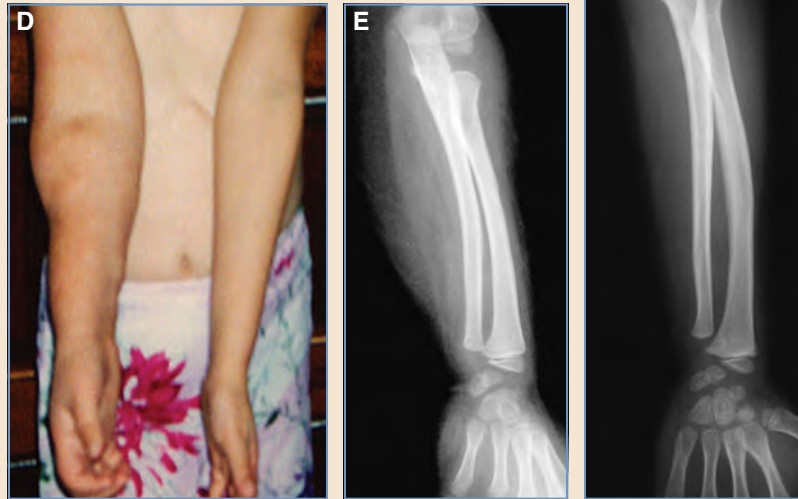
cont'd D, At 9 years of age, the patient continues to have a very swollen arm with very limited wrist extension and tight extrinsic flexors of the forearm, which she cannot supinate because of the tight pronator teres muscle tendon unit. A moderate-to-severe arrest in longitudinal growth has occurred. E and F, Radiographs show no marked changes in the appearance of these tubular bones and growth plates on the right side. This forearm and hand are used primarily in a helping capacity.
